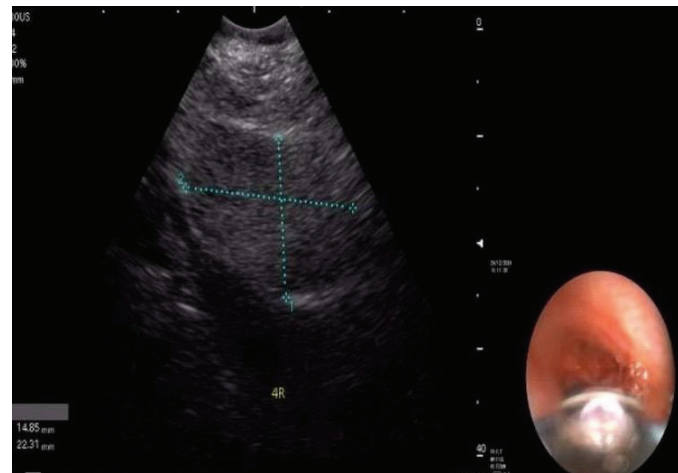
Endobronchial ultrasound image.
